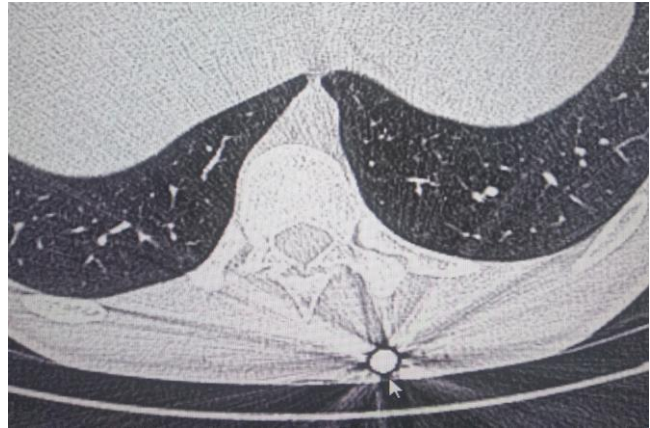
Computed tomography image (arrow) showing bullet in the left thoracic wall
